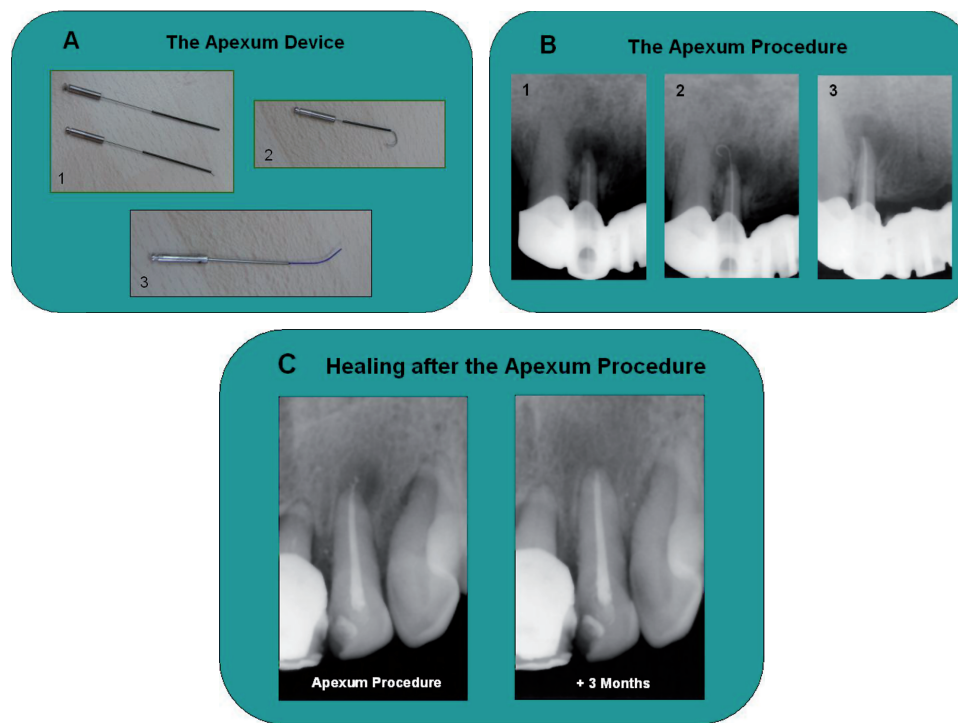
Apexum©: A method for minimally invasive removal of periapical tissues through the root canal. *A*, The Apexum NiTi Ablator© (1, 2). The black tube contains a nickel–titanium wire that is protruded when pushed through the apical foramen. Upon entering the periapical area, it takes a specially designed form (2) and is rotated at 300 rpm, mincing the soft tissue, while being deflected from the surrounding bone. The Apexum PGA Ablator© (3) has a fiber made of biodegradable material that is rotated in the periapical area at 5000 rpm, grinding the tissue to a thin suspension that is then washed out with saline. *B*, (1) The nickel–titanium tube is inserted to the working length. (2) The Apexum NiTi Ablator is pushed and inserted into the periapical area. (3) Once the Apexum procedure is completed, the root canal is obturated with a root canal filling. *C*, A maxillary incisor immediately after the completion of the procedure and 3 months later. Note the rapid bone healing in the periapical area.
